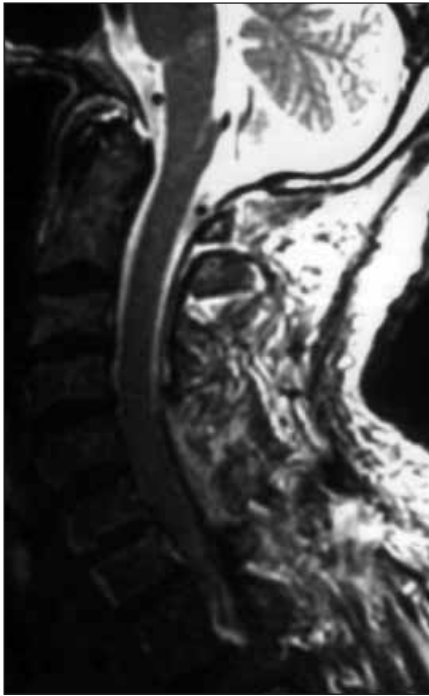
Postoperative T2-weighted magnetic resonance image after evacuation of hematoma and decompression of cervical spinal cord.
